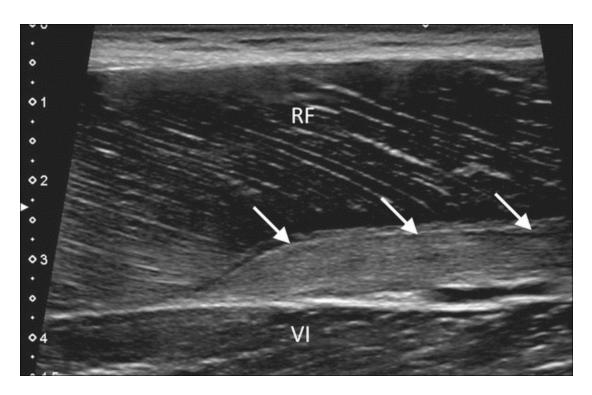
Longitudinal ultrasound image at the mid third of the anterior thigh shows chronic hyperechoic and organized fibrotic tissue (*arrows*) between the rectus femoris and vastus intermedius muscles aponeurosis from chronic hematoma. *RF* rectus femoris, *VI* vastus intermedius
